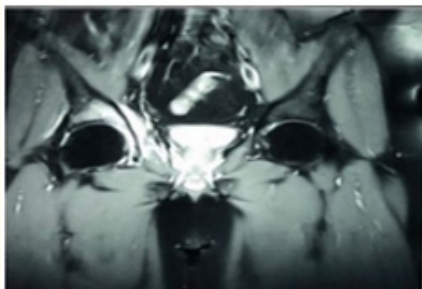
MRI suggesting of lytic, enhancing lesion with soft tissue component in right acetabulum.
